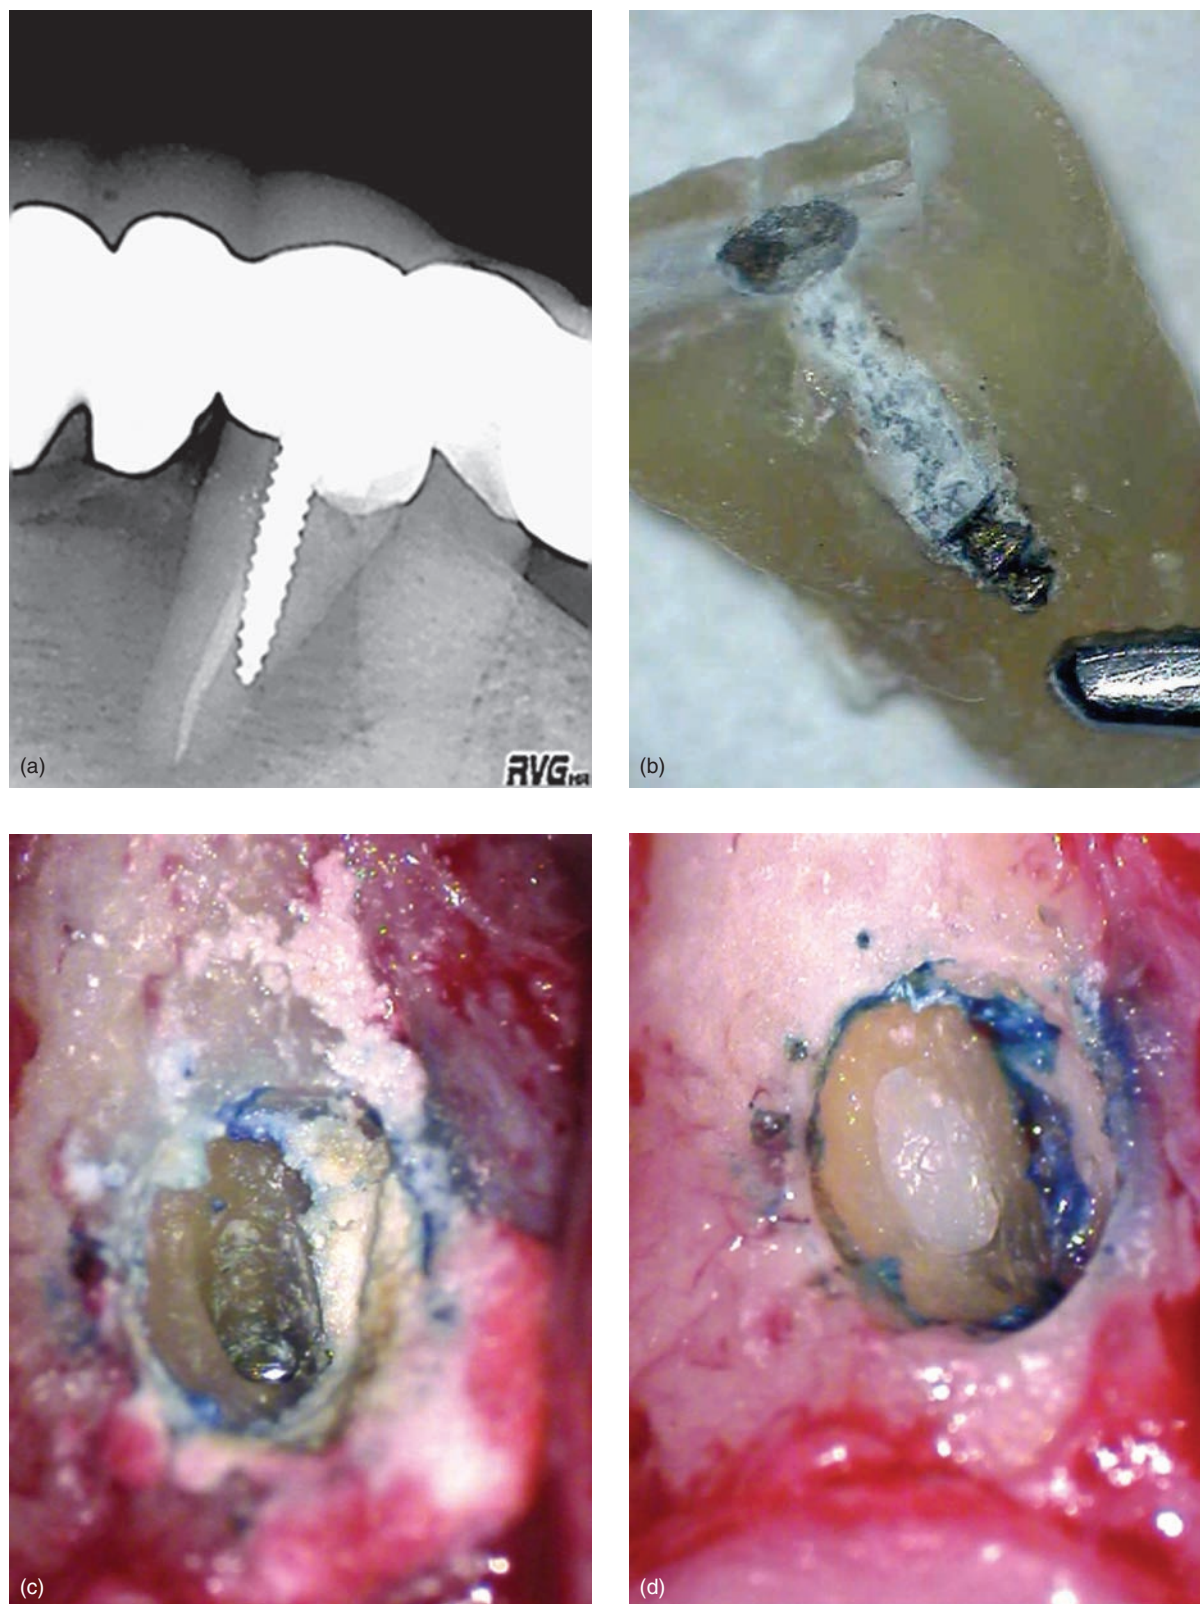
Examples of root perforations. (a) Radiograph showing a perforation caused by a screw post. (b) Strip perforation in an extracted tooth shows the extent of the damage caused by a screw-type active post. (c) Oval-shape perforation created by a post space drill. (d) Oval-shape perforation repaired surgically with Geristore.
